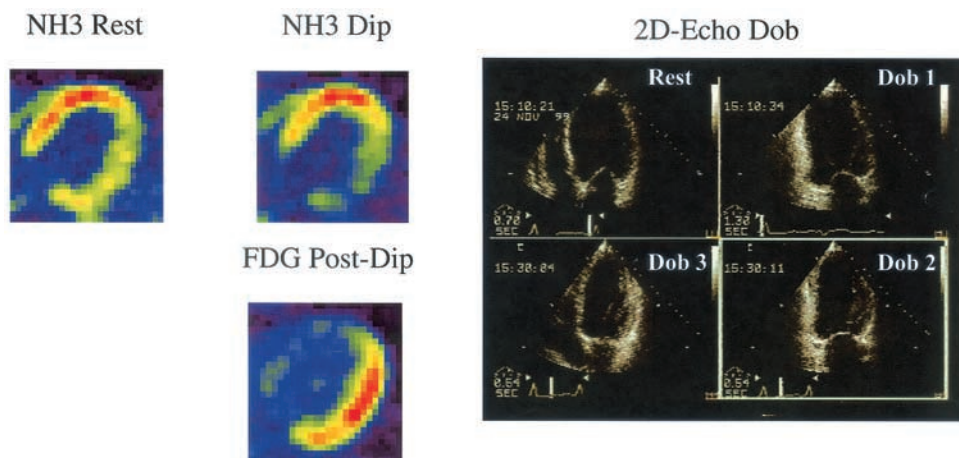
Left, Left ventricular myocardial transaxial slices obtained in a single patient with idiopathic left ventricular dysfunction by PET after injection of N-13 ammonia (*NH3*), as flow tracer, at rest and after intravenous dipyridamole (*NH3 Dip*) and after injection of F-18 fluorodeoxyglucose, as glucose uptake tracer, 30 minutes after dipyridamole (*FDG Post-Dip*). A regional perfusion defect involving the posterolateral wall of the left ventricle is evident at rest, which becomes more severe during dipyridamole. The same region shows increased glucose uptake (flow-metabolism mismatch pattern). Right, End-systolic 2-dimensional echocardiographic frames from the same patient, obtained in 4-chamber apical view at rest and during increasing doses of dobutamine (*Rest*, resting conditions; *Dob 1*, 5 µg/min; *Dob 2*, 10 µg/min; *Dob 3*, 20 µg/min). The posterolateral wall is akinetic at rest while showing preserved contractility at dobutamine testing.
